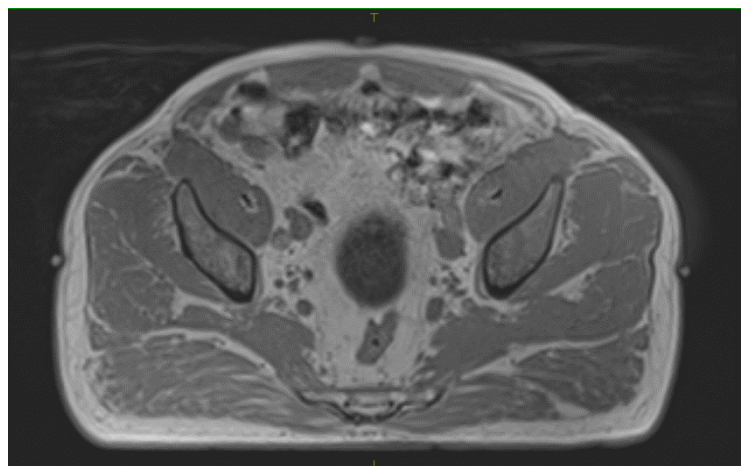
LiquiMark™ MRI Markers.
